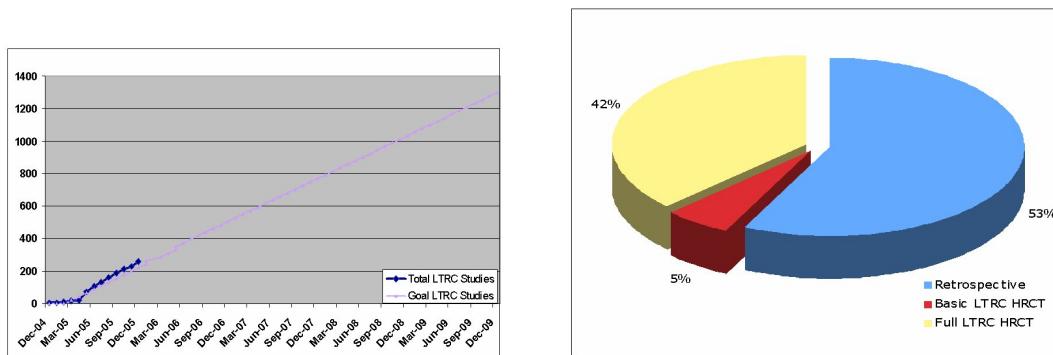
Enrollment for the LTRC is on schedule to include more than 1200 subjects by the end of 2009. Currently, there are over 230 subjects enrolled. Over 40% of patients enrolled thus far have been scanned with the full LTRC three phase protocol. Other subjects have either retrospective or basic LTRC CT scans.
